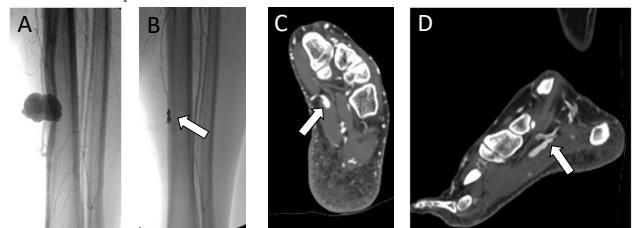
(A,B) Posterior tibial arteriogram before and after coil embolization of a traumatic PSA and AVF. (C,D) CTA of the foot showing a plantar AVF (arrows), which was managed conservatively.
